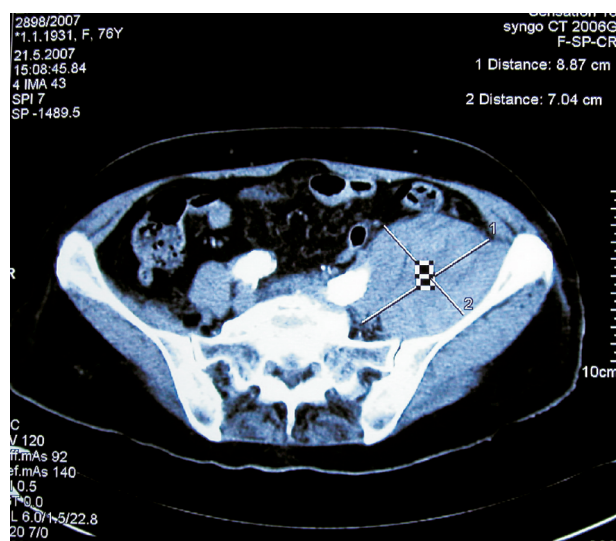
CT scan of lower abdomen/pelvis: visible left sided retroperitoneal hematoma 8.8x7 cm in transverse diameter.
